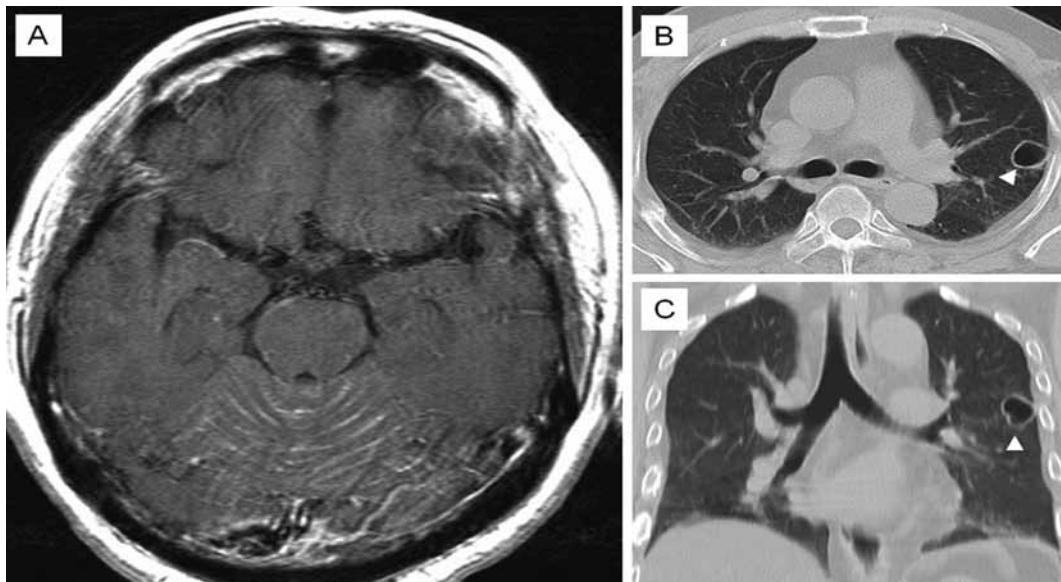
Axial brain MRI with contrast (1A) showing leptomeningeal enhancement over the cerebellum. Axial (1B) and coronal (1C) high resolution chest CT showing a cavitated nodule in the left upper lobe of the lung.
